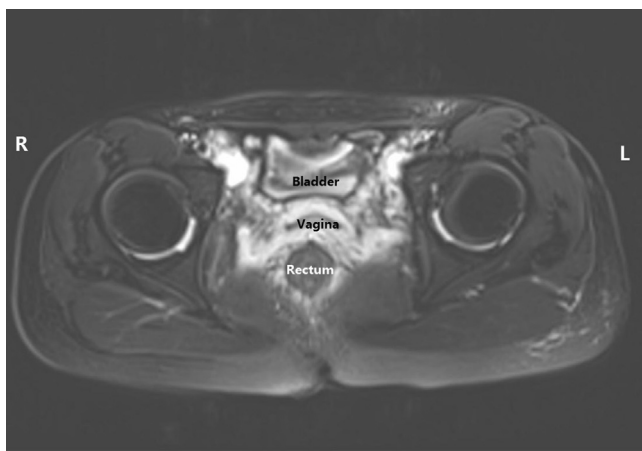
Transverse pelvic T2-weighted magnetic resonance image across vagina. Bright vaginal wall indicated possible lymphatic extravasation, which is the reason for chylous vaginal discharge.
